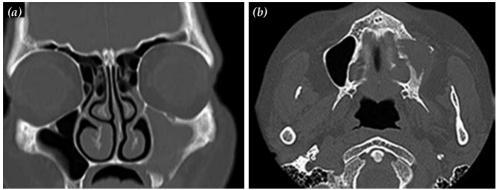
Paranasal Sinus computed tomography scan. (a) Coronal view, (b) Axial view showing large bony defect and accumulation of secretion in left maxillary sinus.
